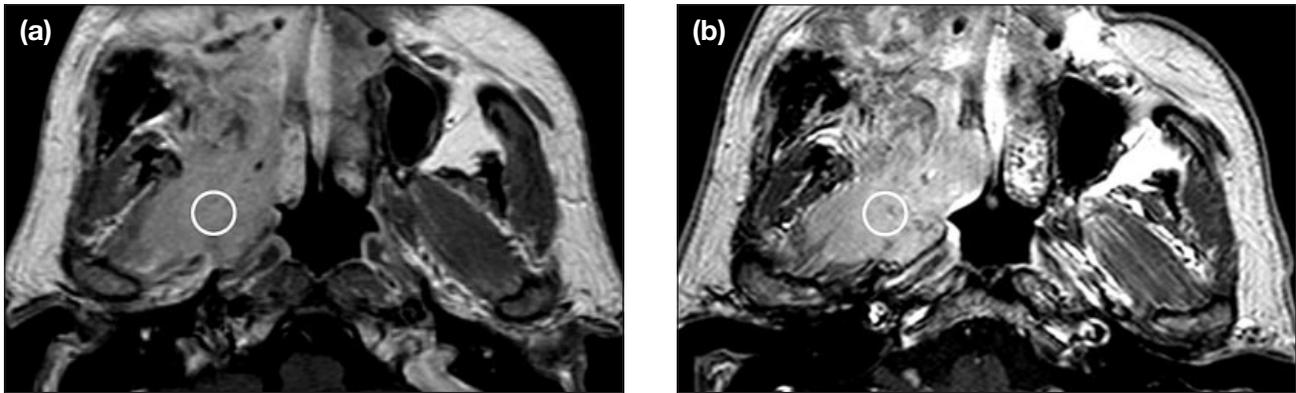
Imaging of a patient with an osteosarcoma at (a) 1.5 Tesla; and (b) 3.0 Tesla. These postcontrast T1-weighted scans show an increase of 36% of the signal-enhancement ratio of the lesion when scanning at 3.0 Tesla. The circle represents the lesion region of interest.
